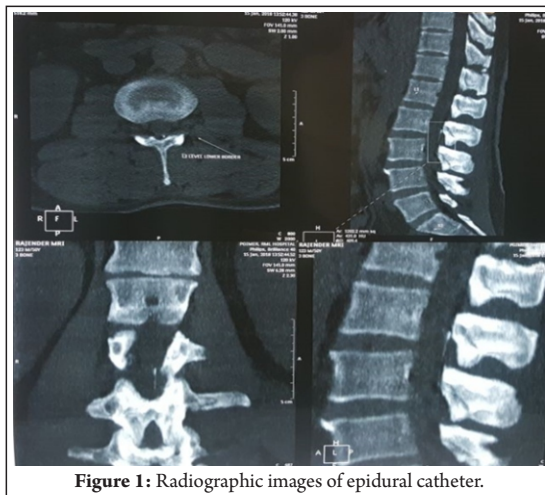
Radiographic images of epidural catheter.
